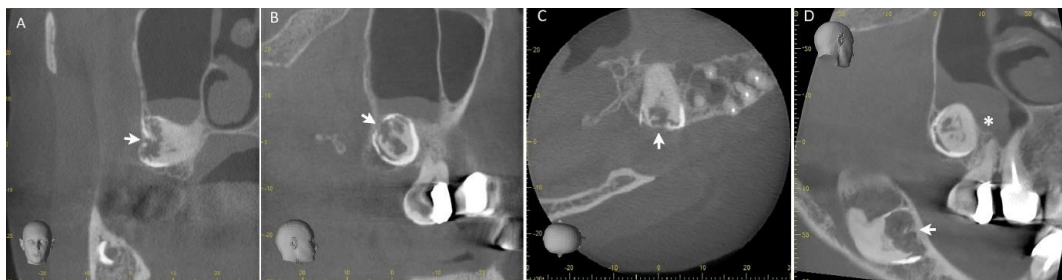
CBCT images of patient 1: Coronal (A) and sagittal (B) images of the maxillary right third molar show the defect extending through the full dentin thickness of the crown (arrows); an axial view (C) reveals a connection (arrow) between the surrounding bone and the defect in the distal intracoronal area.
